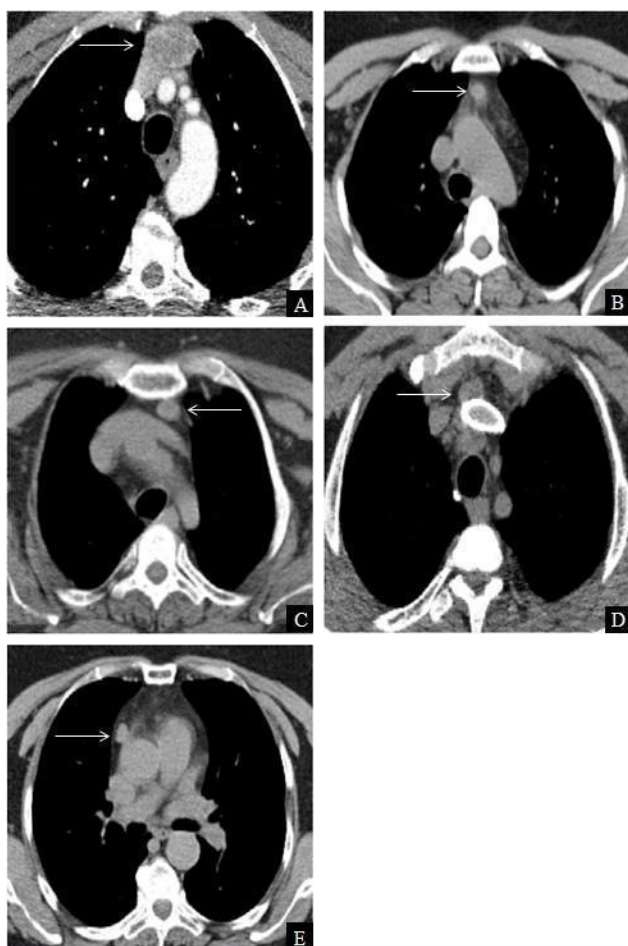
Thoracic computed tomography (CT) findings in Cases 1–5. Axial CT images show well-circumscribed mediastinal soft-tissue lesions (arrows) consistent with ectopic parathyroid adenoma. Panels correspond to individual cases: (A) Case 1; (B) Case 2; (C) Case 3; (D) Case 4 (thoracic inlet/superior mediastinal lesion managed through a transcervical approach); (E) Case 5.
